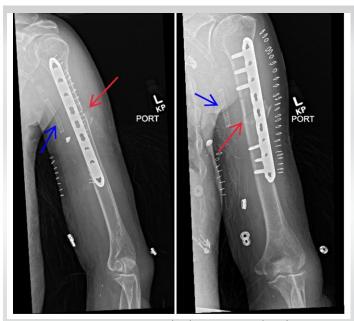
Post-operative sagittal (left) and coronal (right) radiographs following open reduction internal fixation of a left humeral shaft fracture. The fracture line is shown by the red arrows. The left brachial artery stent is shown by the blue arrow. A bone fragment is appreciated at the posterolateral aspect of the fracture line.
